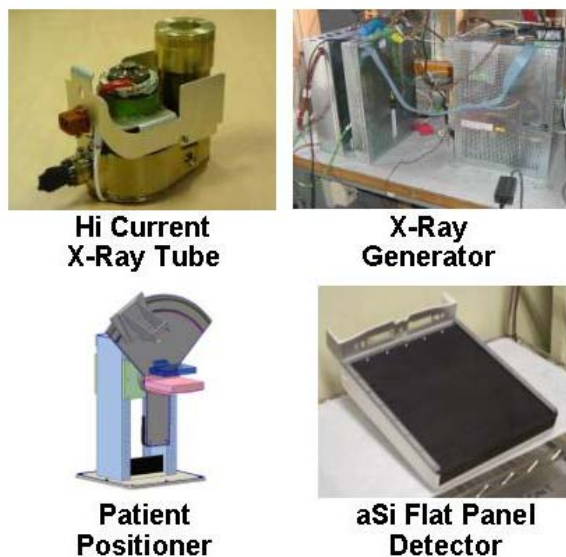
Photograph of the key components of the system. A) x-ray tube, B) generator, c) patient positioner, d) aSi flat panel digital x-ray detector.
